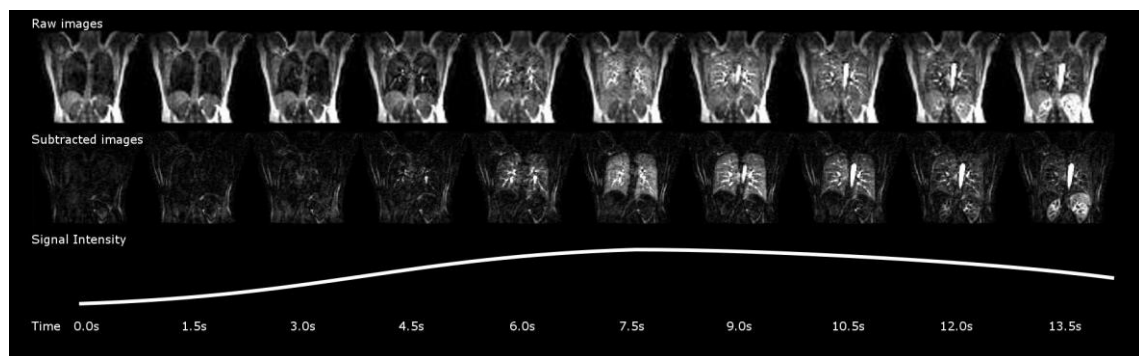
The time-course of DCE-MRI showing a single coronal slice in a healthy volunteer. *The top row of images shows the non-subtracted “raw” images, the second row shows the subtracted images and the bottom row shows the pulmonary parenchymal signal change over time. Please note that the images were acquired with a temporal resolution of 0.5 seconds per 3D dataset, but are displayed with a temporal resolution of 1.5 seconds.*
